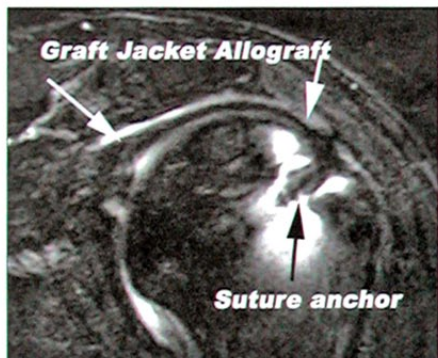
Postop MRI at 1 year showing good healed cuff and muscles. Image courtesy of Stephen J. Snyder, MD, Southern California Orthopedic Institute, Van Nuys, Calif.
